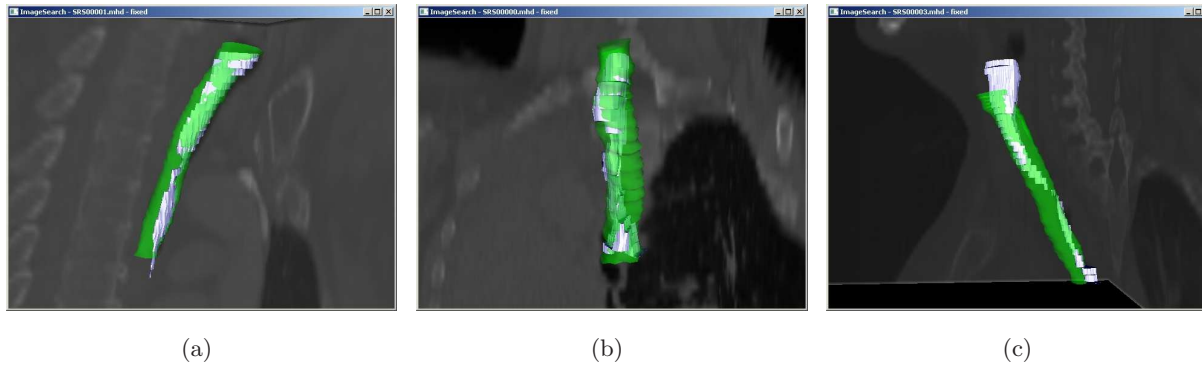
Results of the estimation of the healthy trachea with the *Fixed Landmarks* for patients 1, 2, and 3, from left to right. The estimated trachea, in green, is shown in the CT scan of the patient, overlaid on their segmented stenotic trachea.
